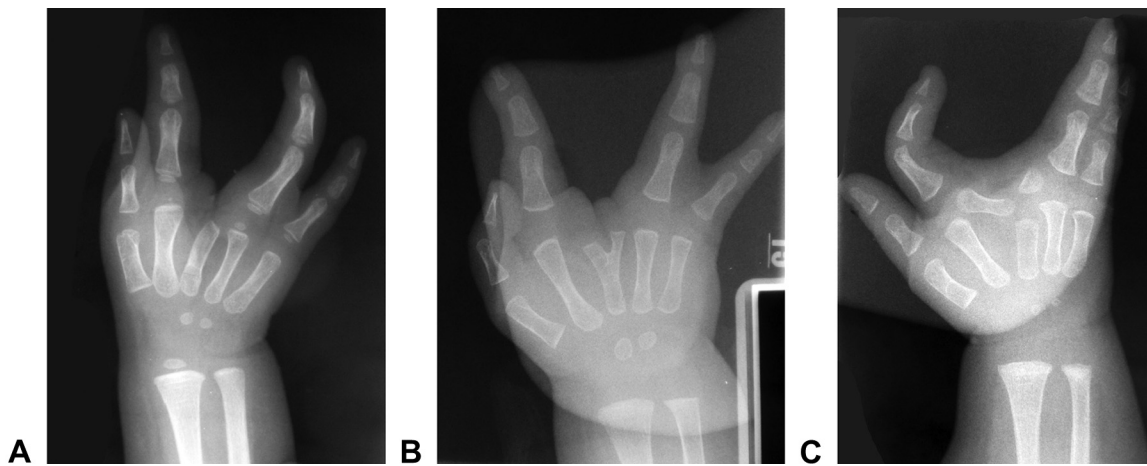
Radiographs of different phenotypic presentations of cleft hand. A Cleft hand without transverse component. B Bifid metacarpal. C Transverse phalanx.
